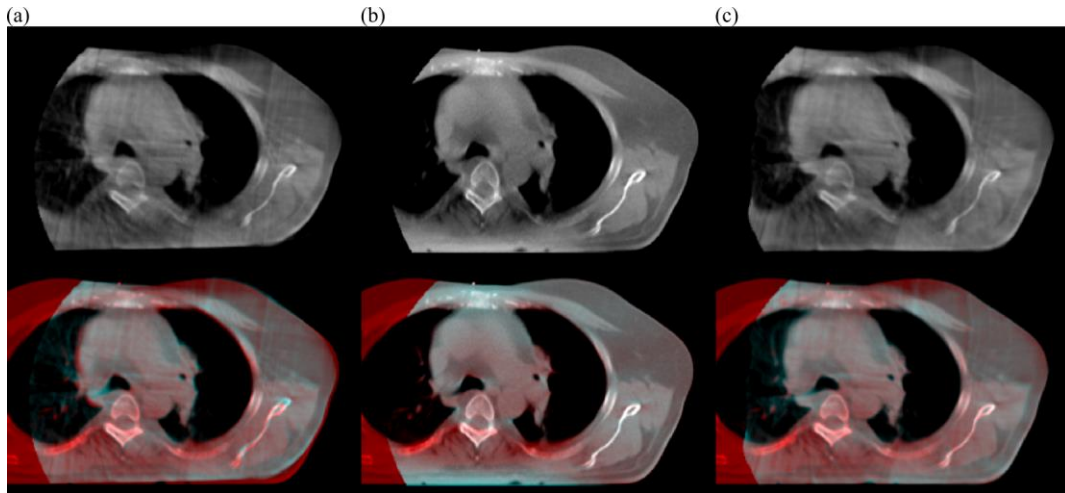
Example of (a) rCBCT, (b) sCBCT, and (c) vCBCT for one of the patients included in this study (top row), and corresponding CBCT (cyan) color overlay with the rCT (red).
